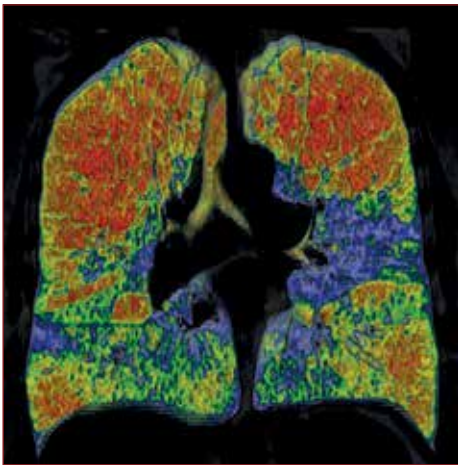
Coronal CT scan with densitometry in a patient with heterogeneous, upper-lobe predominant emphysema. The red color indicates areas with less ventilation.
